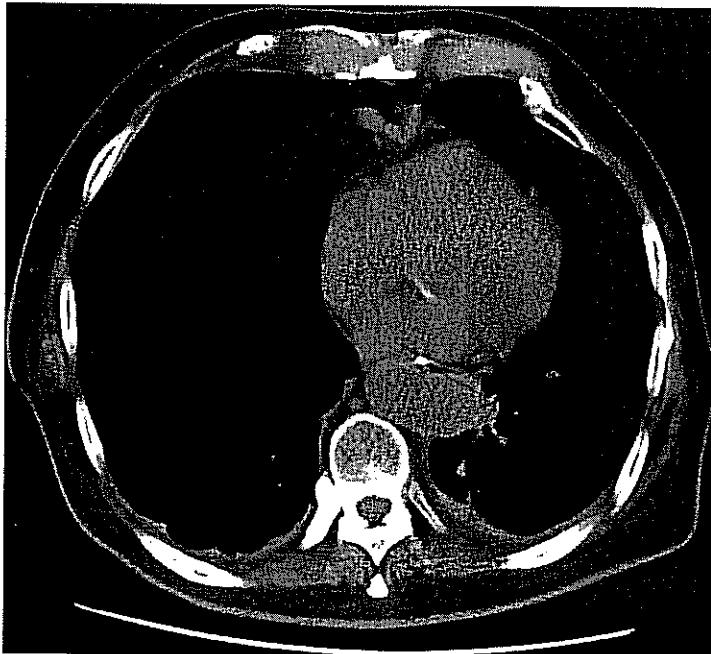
A preoperative CT scan of an 85-year-old patient depicting a porcelain aortic root. Note the nearly completely calcified left coronary system. The patient had a patent retrosternal right internal thoracic artery graft to the left anterior descending coronary artery bypass graft and patent left internal thoracic artery to obtuse marginal coronary artery bypass graft. These cases have been performed with alternative axillary or femoral artery cannulation with a period of hypothermic circulatory arrest to replace or endarterectomize the aortic root and ascending aorta. Morbidity and mortality have been high with this approach because of the risk of complications related to dissection, embolization, and bleeding.<sup>1-4</sup> A 30-day mortality of 9% and mid-term survival of 40% have been reported in a series using this technique.<sup>3</sup> Other patients for whom one would consider the apical approach are those presenting with an extremely risky redo sternotomy. Potential situations include previously placed patent arterial grafts tightly adherent to the posterior sternum in the midline, multiple previous sternotomies, or previous mediastinal radiation, or a situation in which a patient has a retrosternal colonic interposition.<sup>5</sup>
